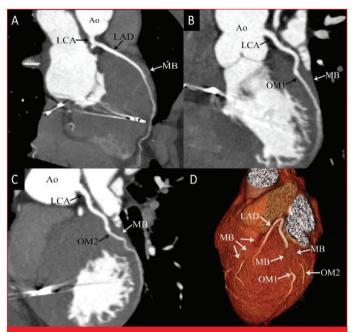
Example of myocardial bridging on cardiac coronary computed tomography angiography in a HCM patient. Respectively, modified 2 chamber and short axis view demonstrating myocardial bridging of the left anterior descending artery (depth:4.5 mm, length: 45 mm) (A) and the first (depth:4.8 mm, length: 35 mm) and second (depth:4.1 mm, length: 22 mm) obtuse marginal arteries (B, C). Three dimensional reconstruction showing myocardial bridging of the left anterior descending artery and obtuse marginal arteries (white arrow) (D). Ao: Aort, LCA: Left main coronary artery, LAD: Left anterior descending, MB: Myocardial bridging, OM1: The first obtuse marginal artery, OM2: Second obtuse marginal artery.
